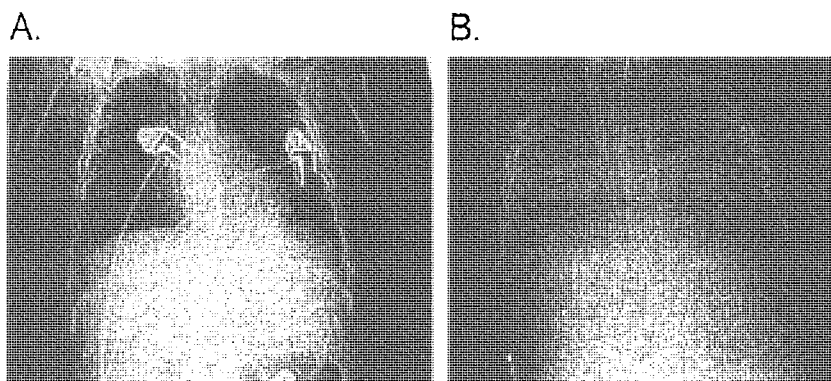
(A) A 2-year-old child with a history of asthma presented to the hospital with tachypnea and fever. The chest X-ray shown here showed patchy airspace disease in the left base, interpreted to be patchy atelectasis associated with asthma. (B) Less than 24 h later, the child's condition had rapidly deteriorated. This chest X-ray shows bilateral airspace opacification of both lungs. MRSA was isolated from the airway of this child and from the lungs at postmortem examination.
